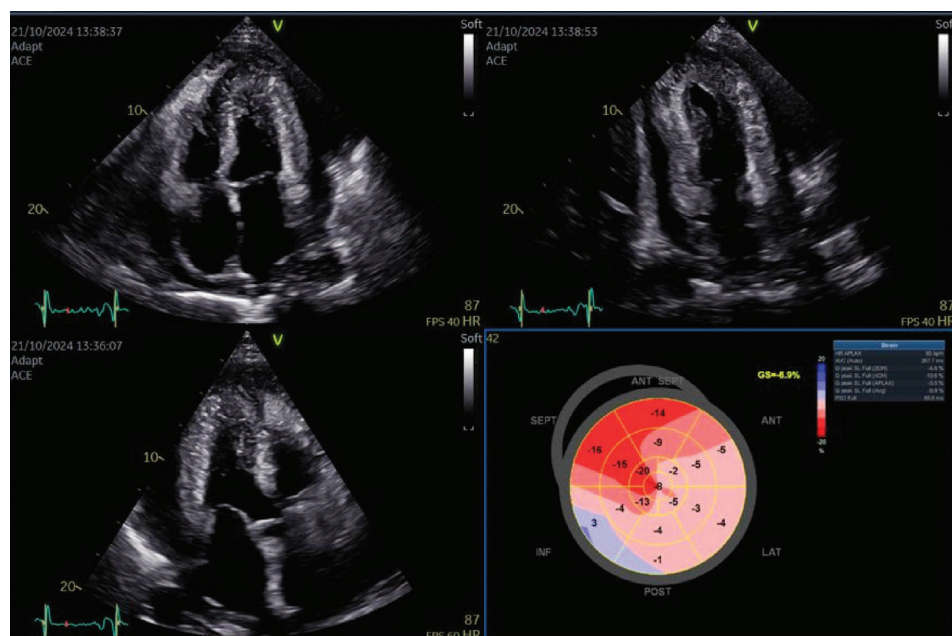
Transthoracic echocardiography: apical four chamber view (upper left image), apical two chamber view (upper right image), three chamber view (lower left image) and "bull's eye" of longitudinal systolic function of the left ventricle (lower right image).
